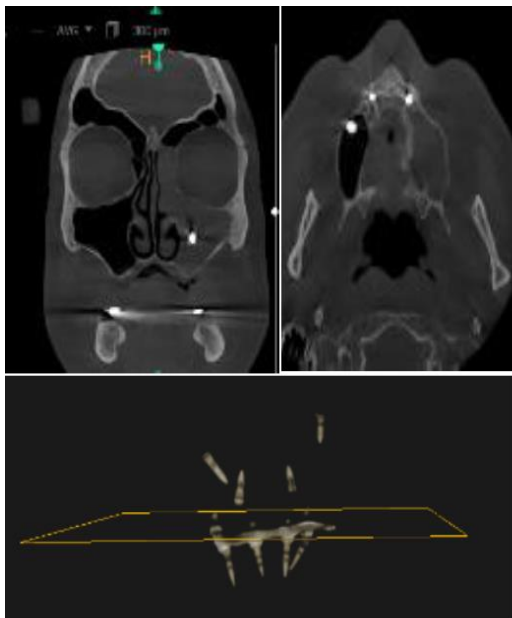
CT scans in sections: A – Coronal; B- Axial; C – 3D Reconstruction.
